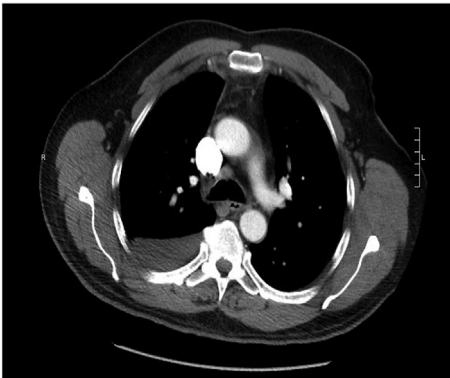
CT mediastinal view of the chest with lymphadenopathy.
